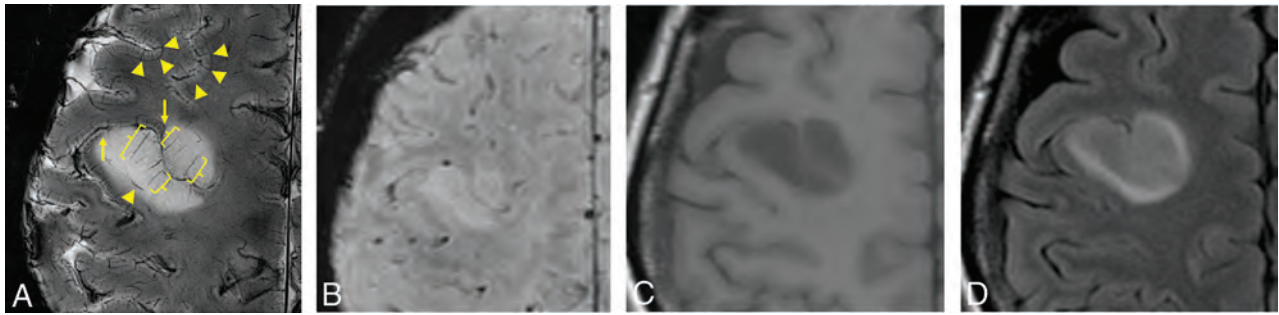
Comparison of 7T SWI and 3T MR imaging. Displacement of the corticomедullary junction, seen as a hypointense band (*triangles*), and elongation of medullary veins running perpendicular to the cortical surface (*brackets*) can be observed on 7T SWI (spatial resolution, $0.156 \times 0.156 \times 3$ mm; total scan time, 3 minutes and 48 seconds; number of slices, 5) (A), which cannot be appreciated on 3T SWI ($0.653 \times 0.653 \times 2$ mm; 4 minutes and 12 seconds; 64 slices) (B), 3T T1-weighted images (C), or 3T FLAIR images (D) obtained on a 3T clinical scanner. Apparent cortical thickening was observed in this diffuse astrocytoma, giving the impression of an oligodendroglioma. However, on close inspection, tapering of the cortex is observed at the edges of the lesion (A, *arrows*).
